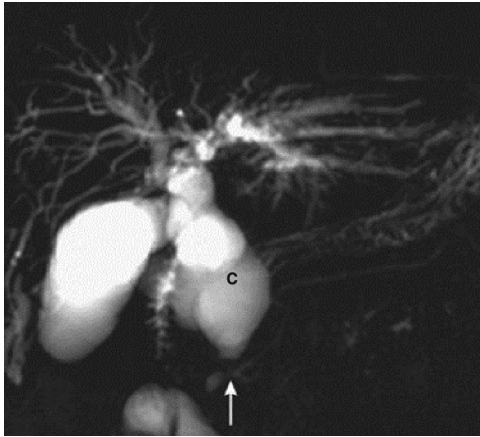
Magnetic resonance cholangiopancreatography demonstrating a pediatric Todani type I choledochal cyst (C) and common bile duct–pancreatic duct junction (arrow). (From Lim J, Kim K, Choi D. Biliary tract and gallbladder. In: Haaga J, Dogra V, Forsting M, et al., eds. *CT and MRI of the Whole Body*. 5th ed. Philadelphia: Mosby; 2009:1373-1453.)
